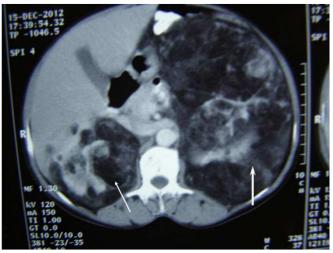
CT scan image with large fat density retroperitoneal mass occupying left renal fossa (Arrow head) and similar small area in right kidney (Arrow)
